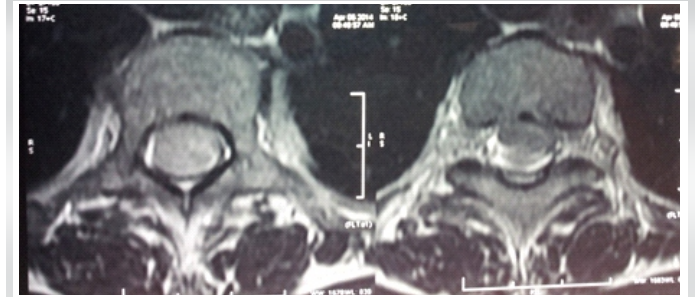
MRI T2 axial image showing dural based meningioma
